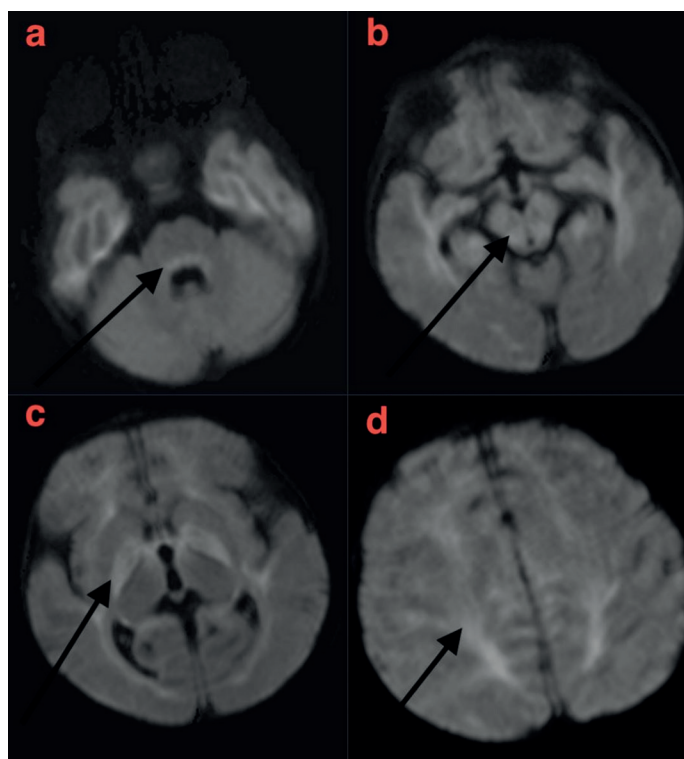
Diffusion Weighted Brain Magnetic Resonance Imaging Restricted diffusion marked with arrow a. cerebellum b. cerebral peduncles c. posterior limbs of the internal capsules d. perirolandic cortex.
